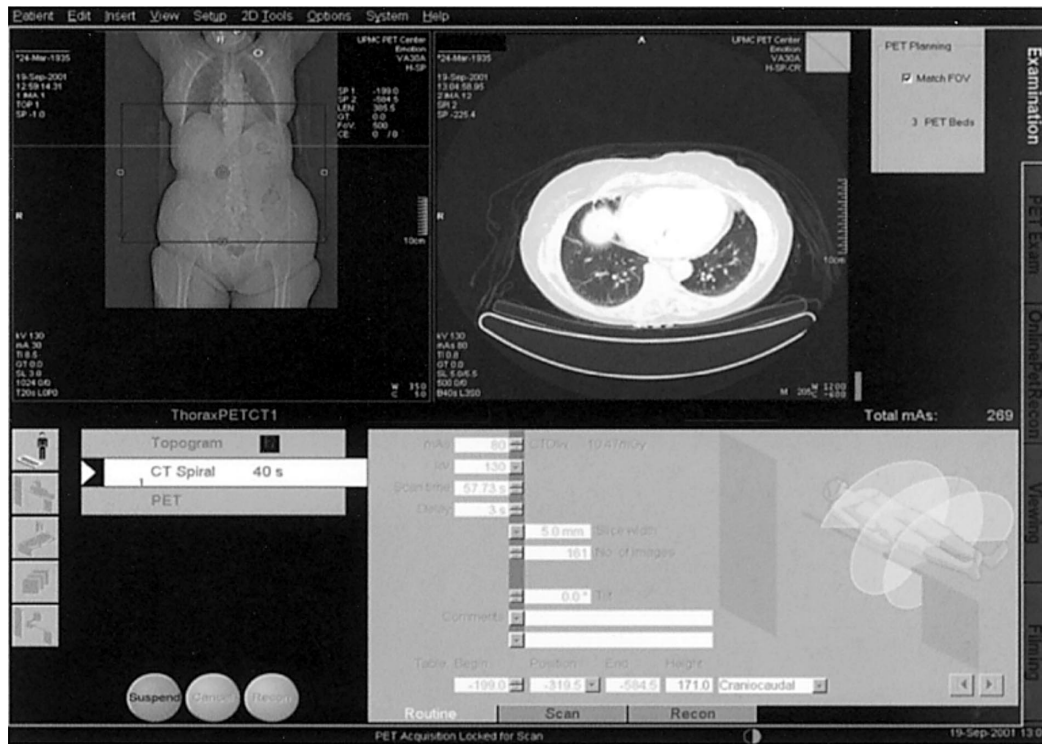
The syngo-based user interface for the biograph PET/CT displaying the CT examination task card and showing the topogram (top, left) with a single reconstructed transverse CT section (center). Scanner controls are in the bottom left of the screen.
